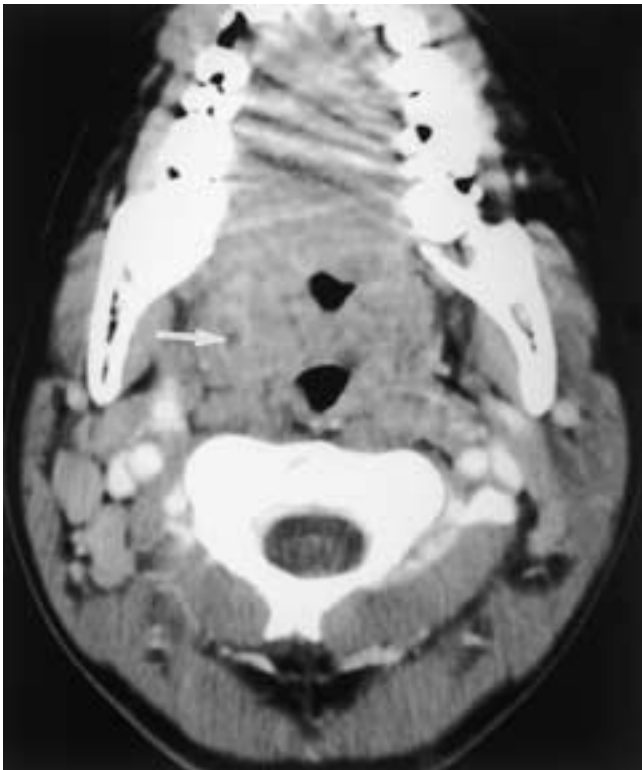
Streptococcal tonsillitis and lymphadenitis in an 11-year-old boy. Contrast-enhanced CT reveals heterogeneous streaky enhancement of the enlarged palatine tonsils with a focus of low attenuation (*arrow*).
